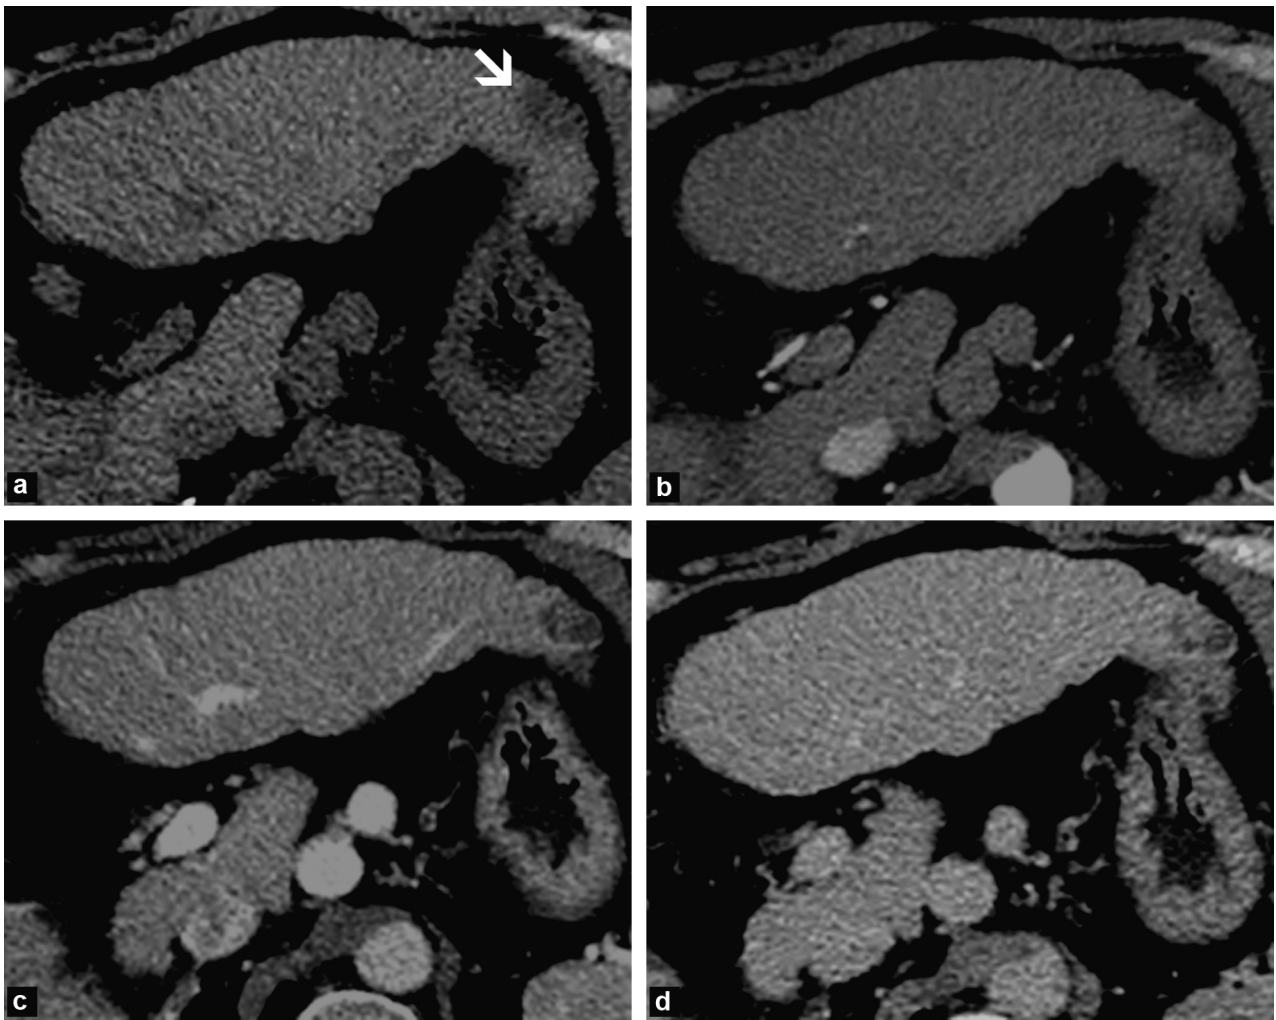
Cholangiocarcinoma. Monitoring examination for cirrhosis of exogenous origin. CT scan without (a) and after injection of an iodinated contrast agent in the arterial (b), portal (c) and late (d) phases: peripheral cholangiocarcinoma of the tip of the left lobe of the liver (arrow), spontaneously hypodense, without arterial hypervascularisation, with incomplete peripheral enhancement in the late phase (d).
